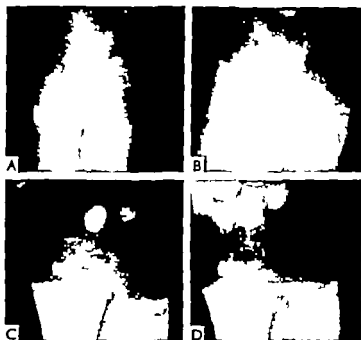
Radiographs of the right wrist. A: On day 1 before treatment. B: On day 49, after 3 weeks of treatment. C: On day 56, after 7 weeks of treatment. D: On day 72, after 9 weeks of treatment.
